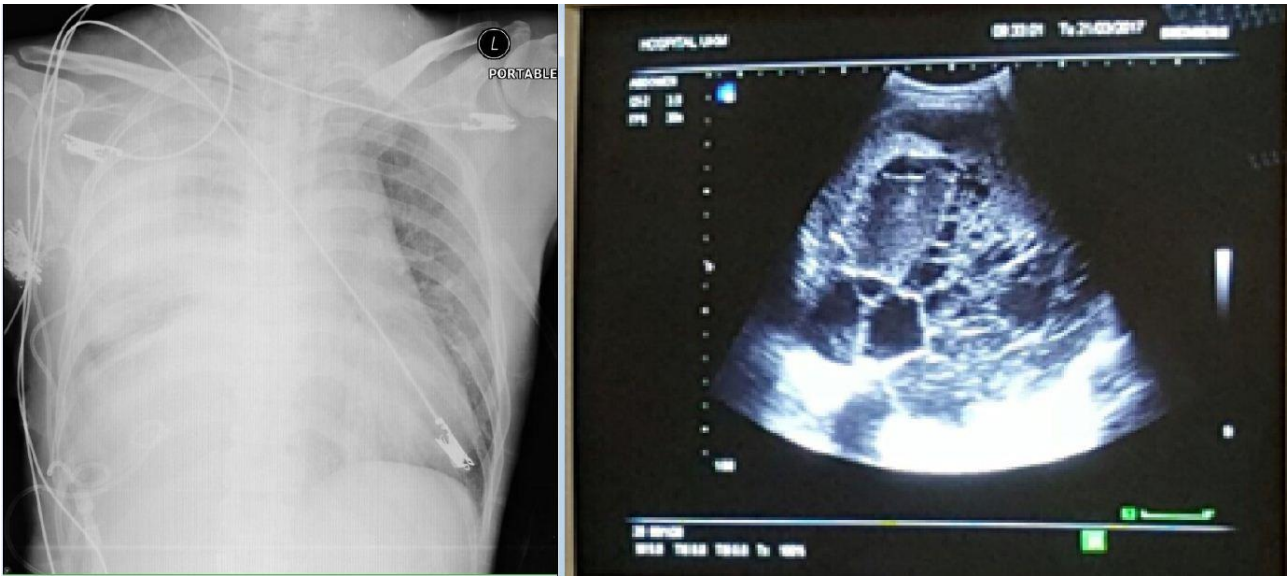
Chest radiograph showed massive right-sided pleural effusion
